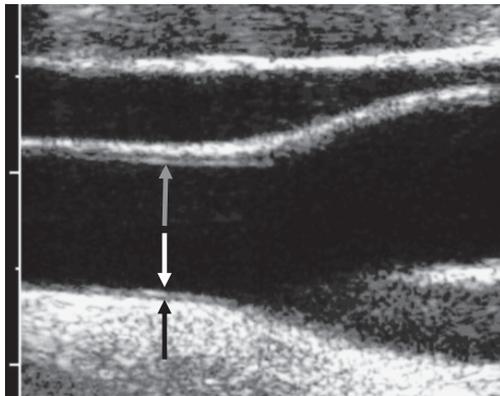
cIMT and CAC were measured from B-mode ultrasound scans. Area between the white (lumen-intima interface, far wall) and the black arrow (media-adventitia interface) indicates intima-media layer in the ultrasound image. The distance between near wall (grey arrow) and far wall (white arrow) of lumen- intima interface in diastole and systole was used to calculate the CAC.
